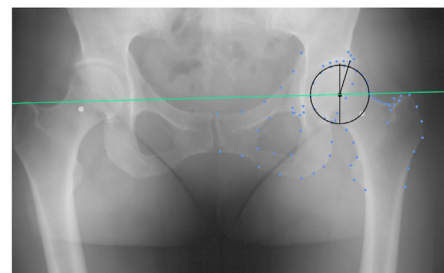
AP pelvic radiograph with automatic Bonefinder search model of hip shape (blue), horizontal reference line (green) and automatic calculation of WCEA (black).
